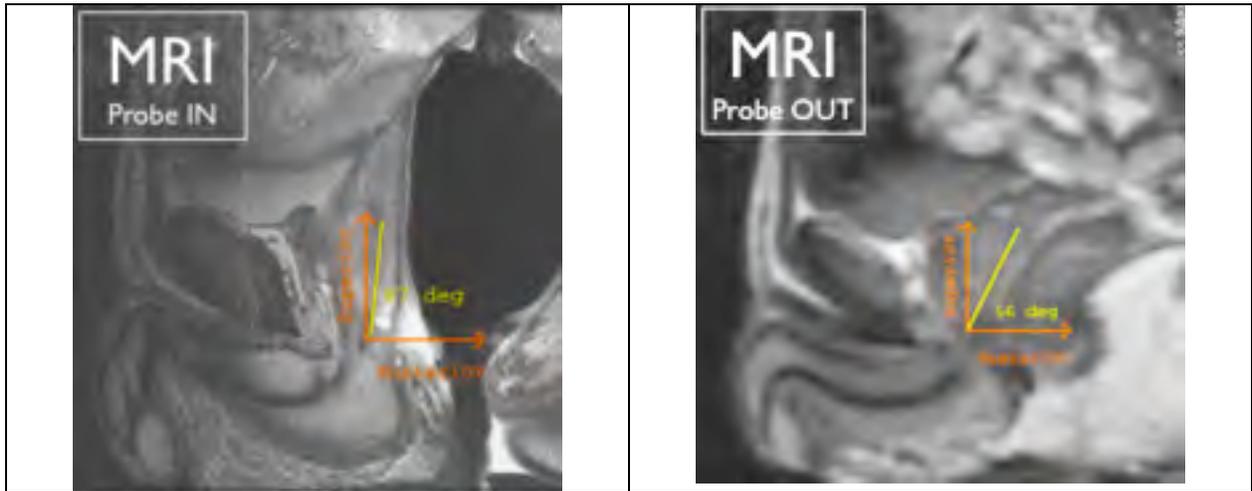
Mid-sagittal MR images showing the prostatic rotation induced by the endorectal coil. The angles were measured between the Y-axis and the peripheral zone / central zone margin.
